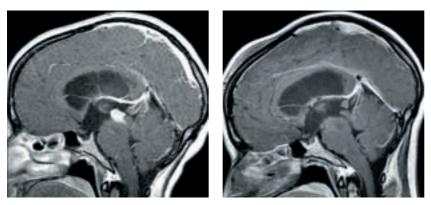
This third ventricular ependymoma shown in the preoperative MRI (left) was removed (right) using a purely endoscopic approach through a far frontal entry site.
